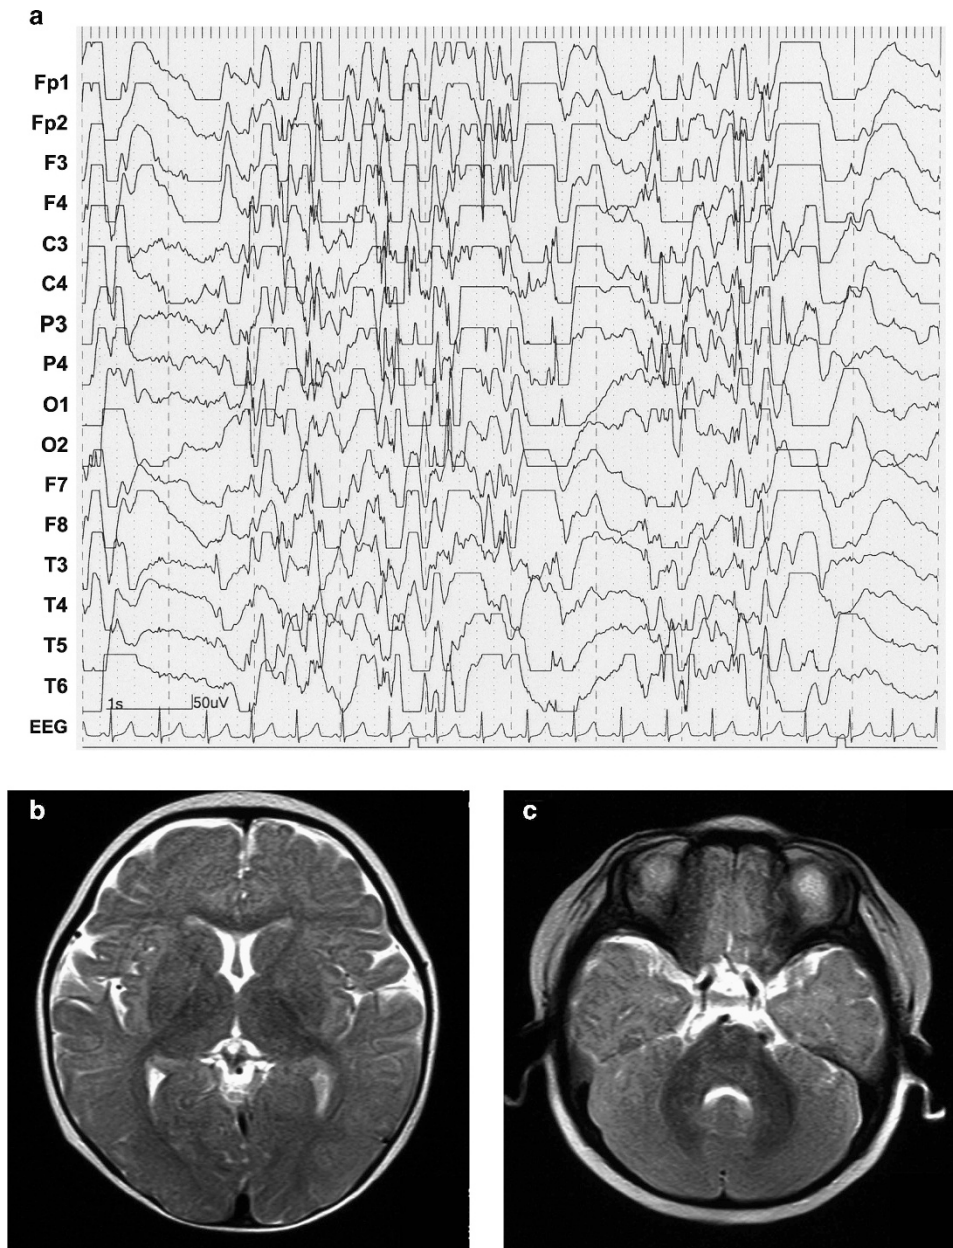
Electroencephalogram (EEG) and brain magnetic resonance imaging in the patient at 7 months of age. (a) Interictal EEG showed high-amplitude multifocal spikes with irregular slow waves consistent with a finding of hypsarrhythmia. T2-weighted axial images through the basal ganglia (b) and the cerebellum (c) showed no abnormalities.
